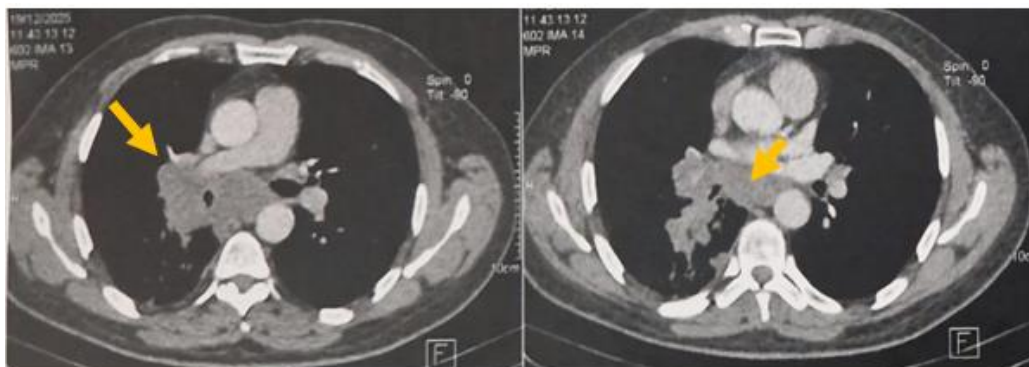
Chest CT demonstrating a right hilar–basal mass with bulky mediastinal lymphadenopathy
